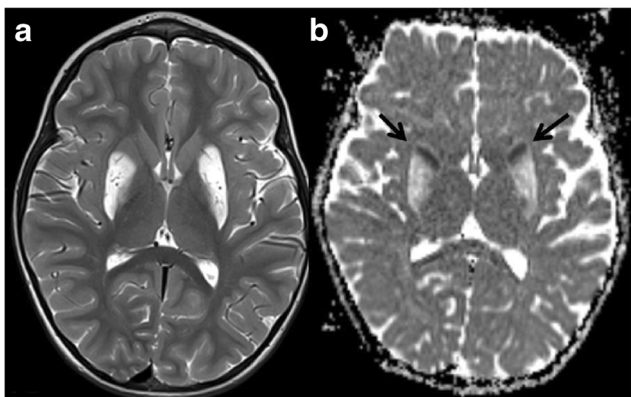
A 6-year-old female patient affected by Leigh disease. Predominant vasogenic edema is noted in the bilateral putamen on T2-weighted images (a) and ADC map (b), with areas of restricted diffusion noted in the most anterior aspects of the putamen (b, black arrows)
